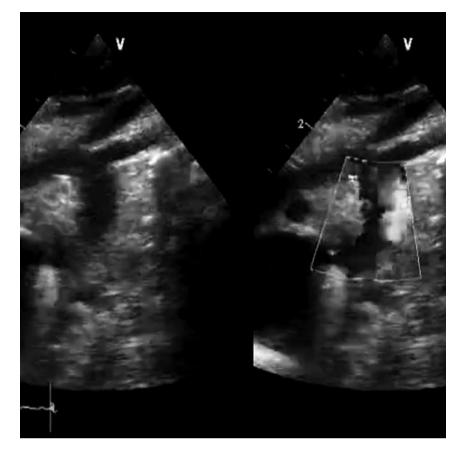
Post-operative echocardiogram depicting laminar flow in the aortic arch.
